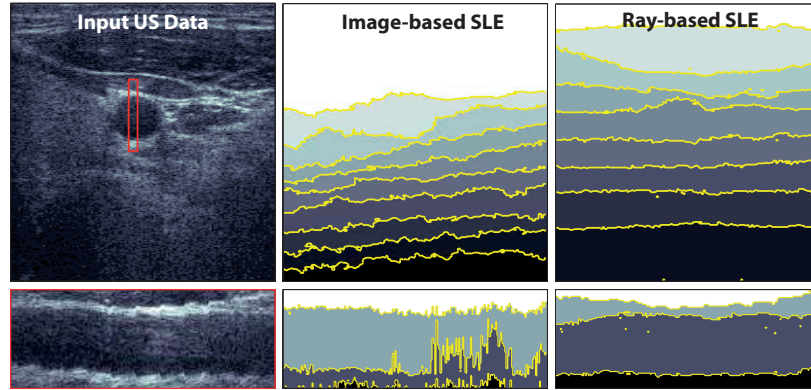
Loss Estimates for Carotid Ultrasound Transverse (top) and longitudinal (bottom) cuts through a 3D acquisition for [75] (middle) compared to the presented method (right) shows much more consistency along the trajectory by using full 3D information.
